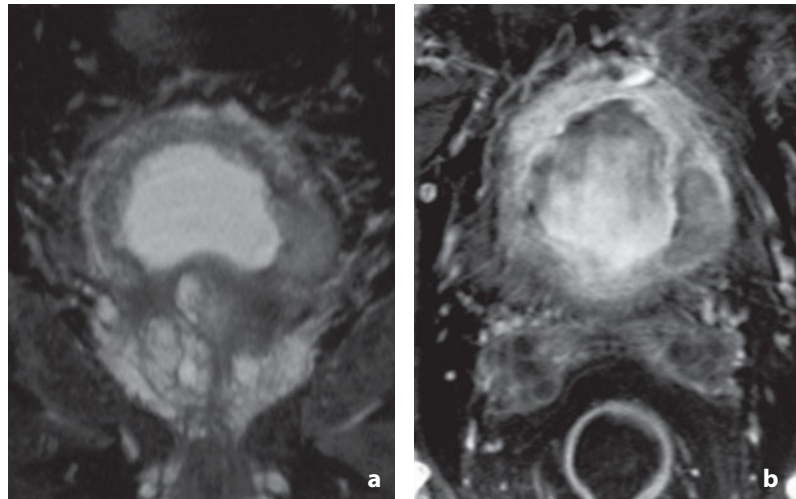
Magnetic resonance. Transition cell carcinoma of the bladder. a T2-weighted image shows thickening of the left lateral bladder wall. b After administration of gadolinium-based contrast medium the local extension of the disease is visible, appearing to involve all layers of the bladder wall while remaining confined to the organ (stage T2b)
